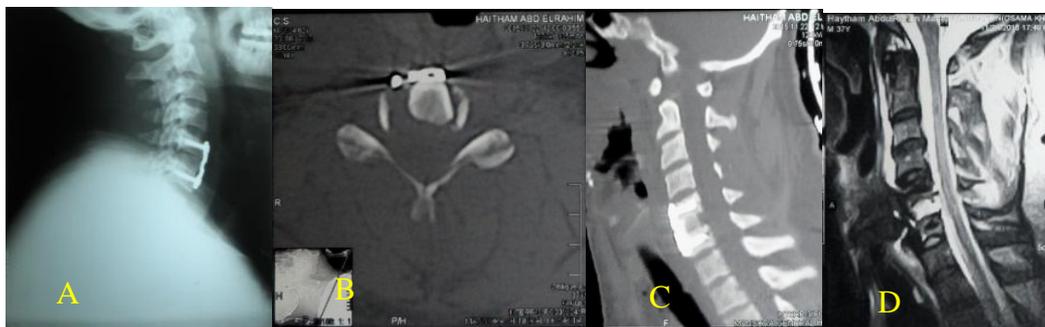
(A) Post-operative plain X-ray, (B) axial CT scan, (C) sagittal CT scan, and (D) sagittal MRI cervical spine views of the previous patient in Fig (3).
